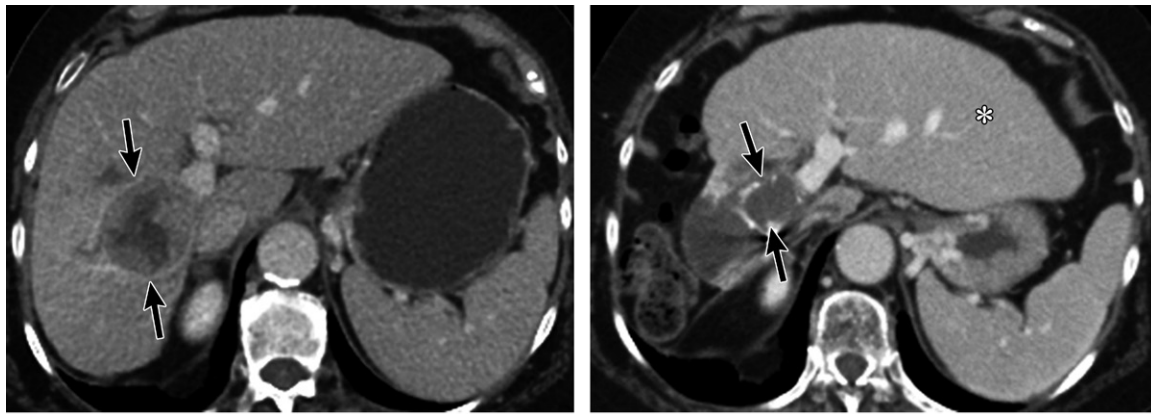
Morphologic changes after TARE in a 51-year-old woman with HCC. (a) Axial pretreatment portal venous phase CT image shows HCC (arrows) in the right liver lobe. (b) Axial post-TARE portal venous phase follow-up CT image shows a complete response of the treated lesion (arrows), with marked atrophy of the treated lobe and contralateral lobar hypertrophy (*).
